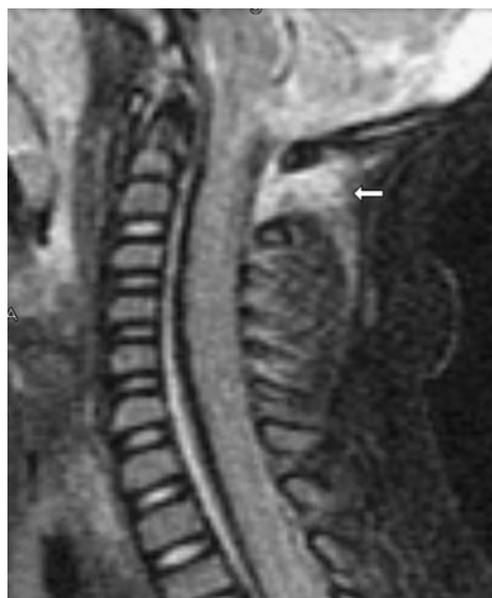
Sagittal MRI showing significant ligamentous injury on the STIR sequence at the upper cervical region (*arrow*)
